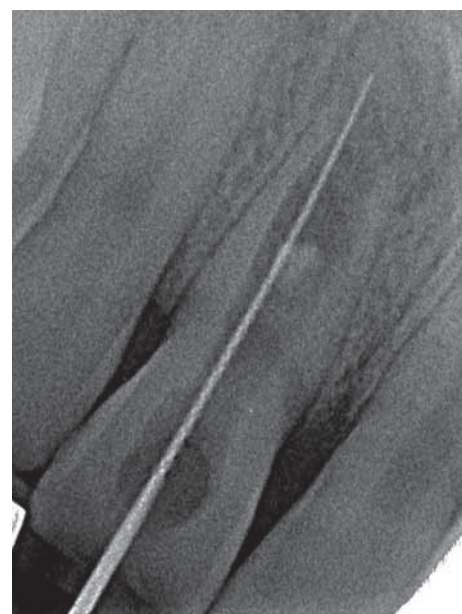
Diagnostic radiograph of the UL1 with a size 20 K-file placed in the canal to determine the working length.
